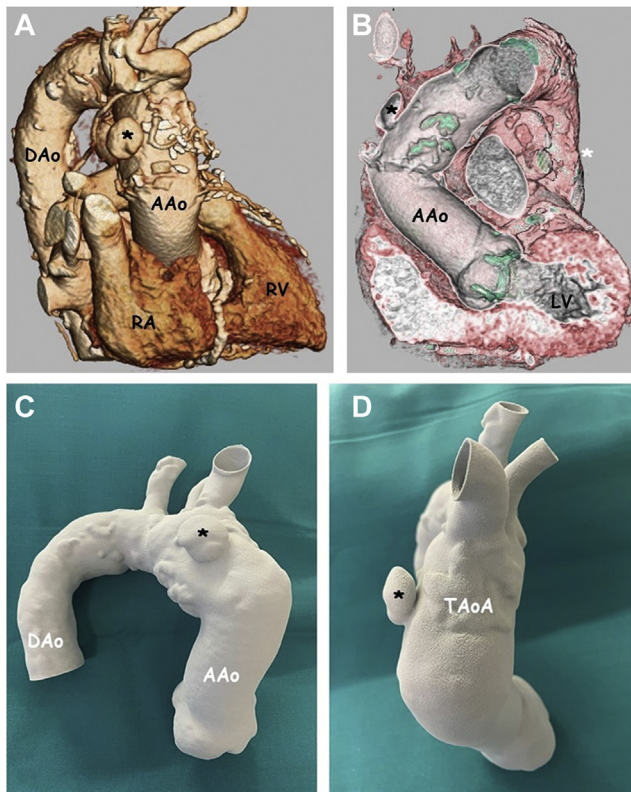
3D Computed Tomography Scan and Printed Model of the Pseudoaneurysmal Pouch Located at the Anterior Surface of the Transverse Aortic Arch
